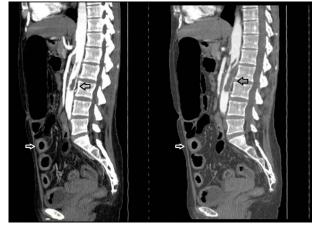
Abdominal computed tomography scan: upper arrows in both panels indicate aortic mural thrombi, lower arrows in both panels indicate thickened small bowel loop due to the Crohn's disease activity flare.
